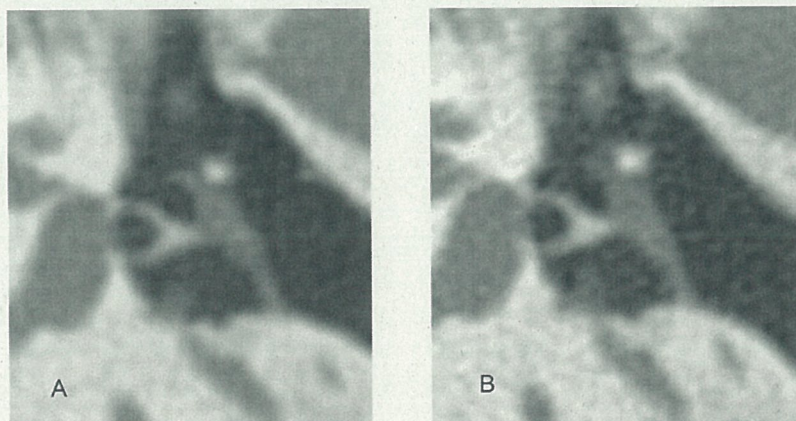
MPR images of the stapes with 4- and 64-detector row CT scanners in the same postoperative ear with cholesteatoma.
